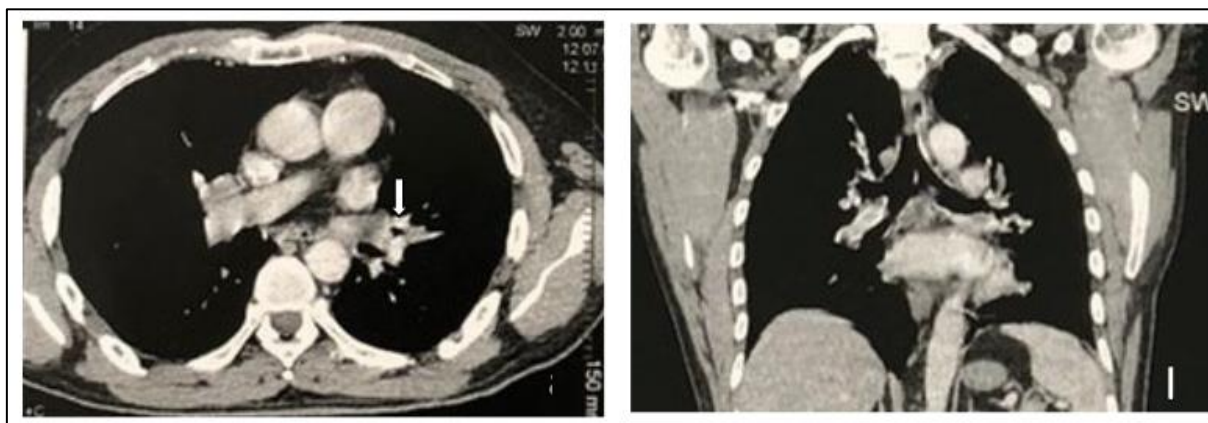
Thoracic CT scan in mediastinal window, axial (a) and coronal (b) sections, showing a poorly limited tissue mass with calcifications, surrounding the left main bronchus and the lingular bronchus with reduction of its caliber
